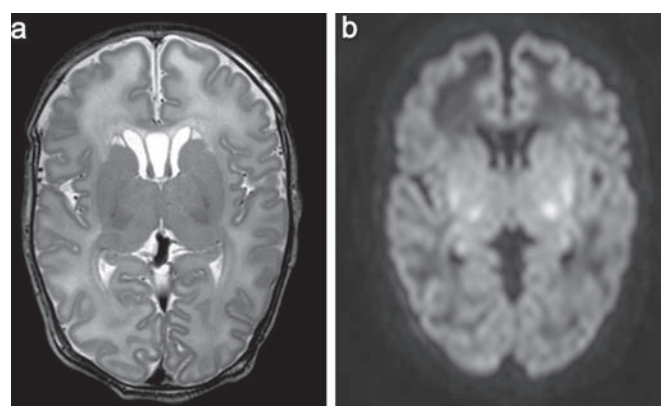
MRI on day 5. (A) T2 weighted spin echo sequence showing a large cavum septum pellucidum and supendymal pseudocysts as incidental findings. The white matter has a high signal intensity, especially anteriorly and the basal ganglia are swollen and the thalami are of lower signal intensity. (B) Diffusion weighted imaging shows low SI in the anterior white matter and areas of restricted diffusion in the ventrolateral thalami and lentiform nuclei bilaterally. Restricted diffusion is also seen at the level of the hippocampi.
